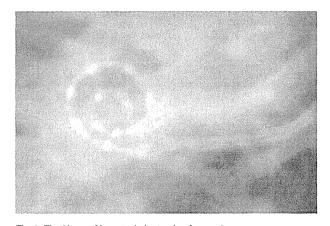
The X-ray of inserted electrode of case 1.
